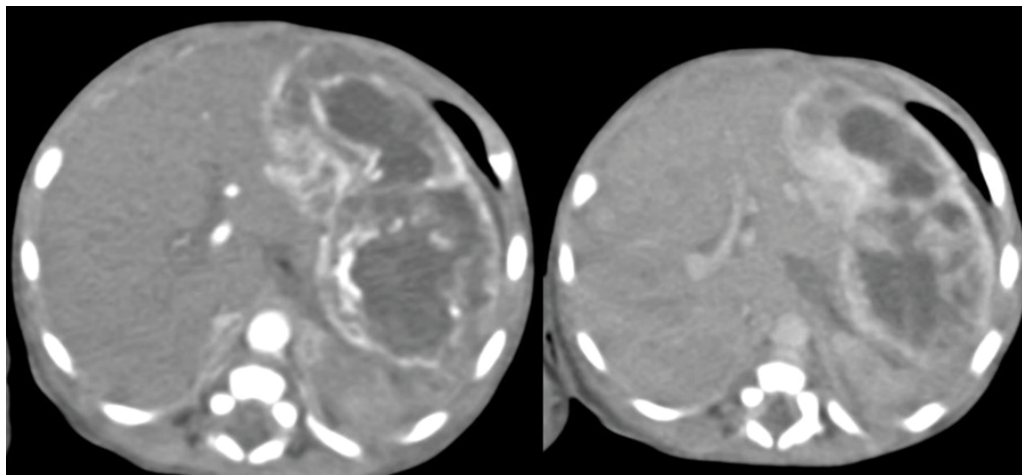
Hemangioendothelioma. Contrast enhanced CT axial sections shows a large lobulated mass seen arising from the left lobe of liver, which displays avid thick peripheral enhancement in arterial phase (a) which is persistent in the subsequent phases (b) with non-enhancing necrotic areas. The mass lesion is supplied by the prominent left hepatic artery.
